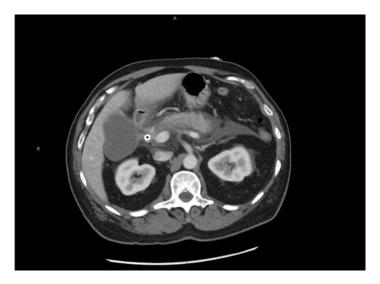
CT scan showing changes of post-ERCP pancreatitis (PEP) after self-expandable metal stent placement. After placement of an 8 mm × 8 cm uncovered metal biliary stent for the treatment of cholangiocarcinoma, the patient developed acute interstitial pancreatitis. CT examination revealed new marked peripancreatic stranding and fluid. Extending in the mesenteric root and bilateral anterior pararenal space. Rectal indomethacin and aggressive fluid hydration were administered during ERCP as part of routine practice. The pancreatic duct was neither cannulated nor injected during the ERCP
